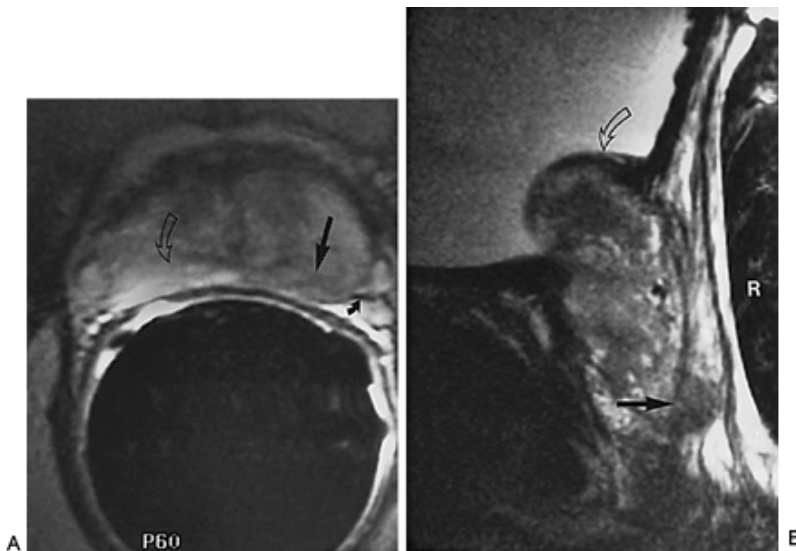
25. Endorectal coil magnetic resonance imaging scan showing T₃ prostate cancer. A: The transverse image demonstrates the hypointense tumor (*black arrow*) involving the left prostatic hemisphere. The tumor abuts and involves the neurovascular bundle. *Curved arrow* demonstrates normal peripheral zone. B: Sagittal view demonstrates the bulging of the capsule (*straight arrow*) from the tumor. Prostatic hyperplastic nodules are seen within the bladder base (*curved arrow*).
